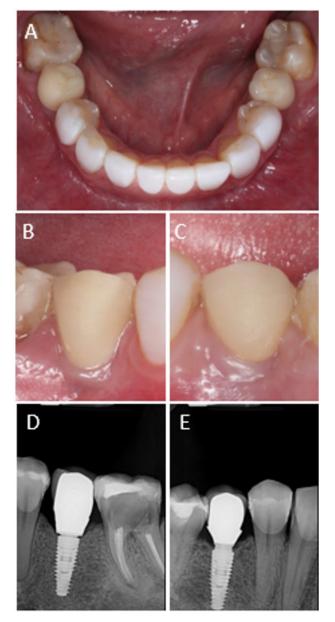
Clinical and radiographic aspects at 30-month follow-up visit. A), B) and C) Occlusal and lateral view of regions 35 and 45. D) and E) Periapical x-rays of #35 and #45.
